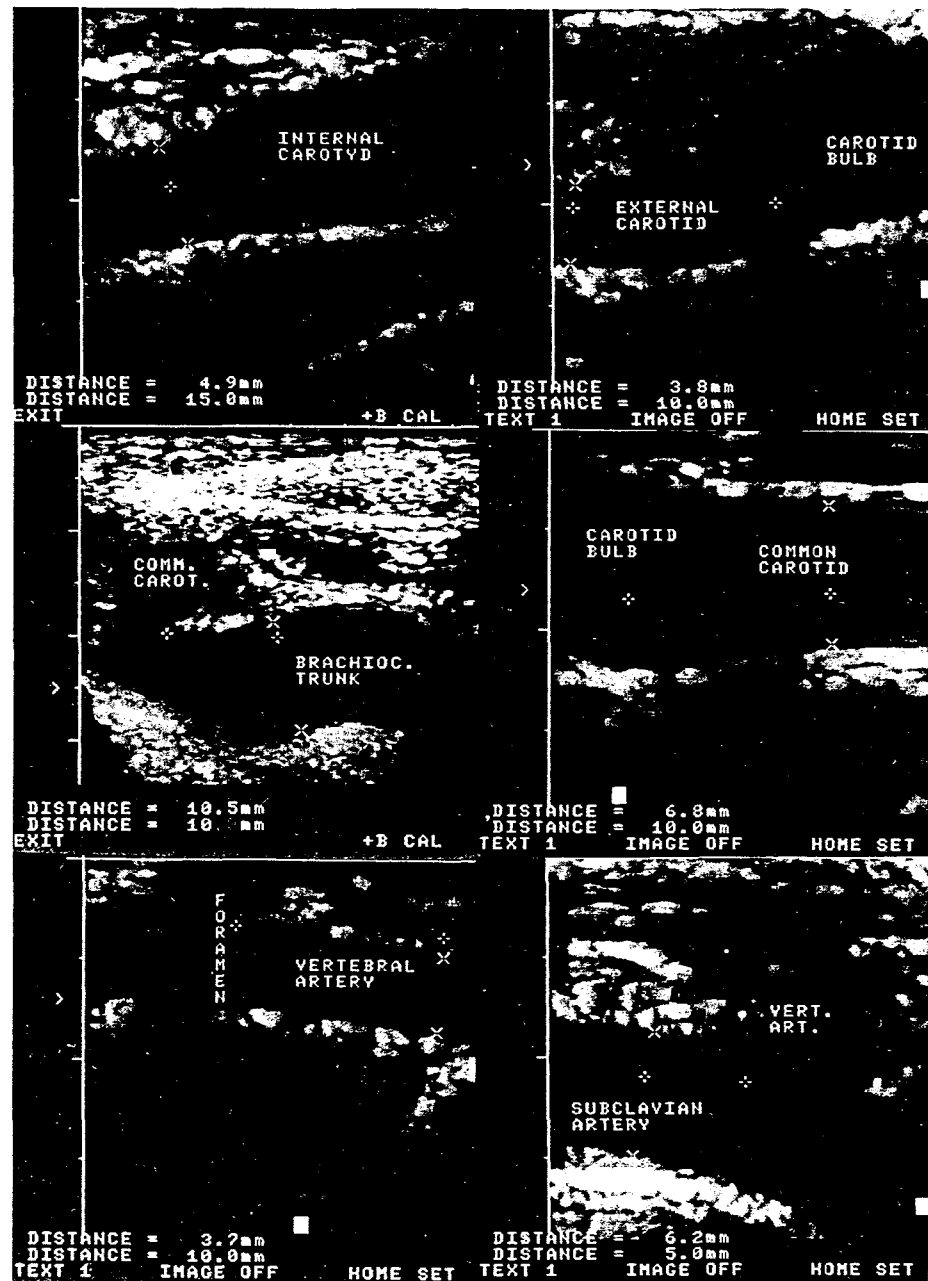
Method of visualization and measurement of the caliber of the arteries examined using Doppler ultrasonography.
